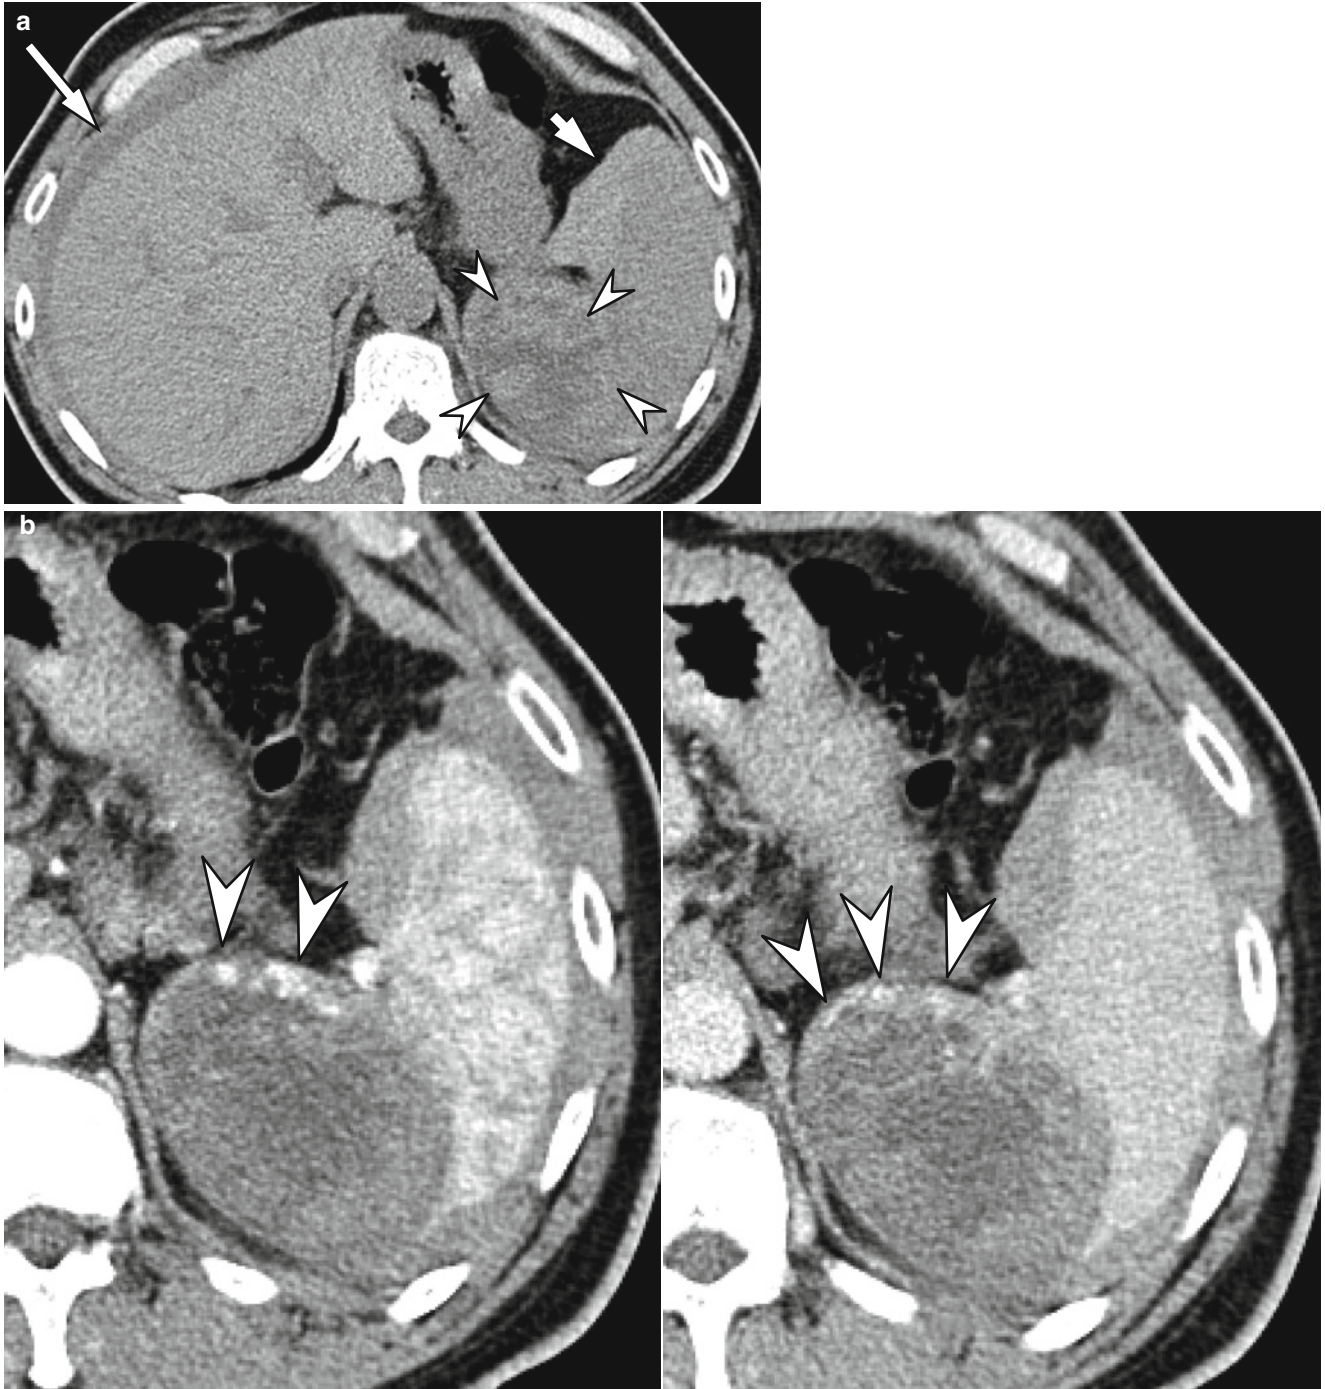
Splenic angiosarcoma with spontaneous rupture in a 41-year-old male. (a) Noncontrast transverse CT image shows acute hematoma (*short arrow*) in the perisplenic space and hemoperitoneum in the perihepatic space (*long arrow*). A large mass lesion is also noted
